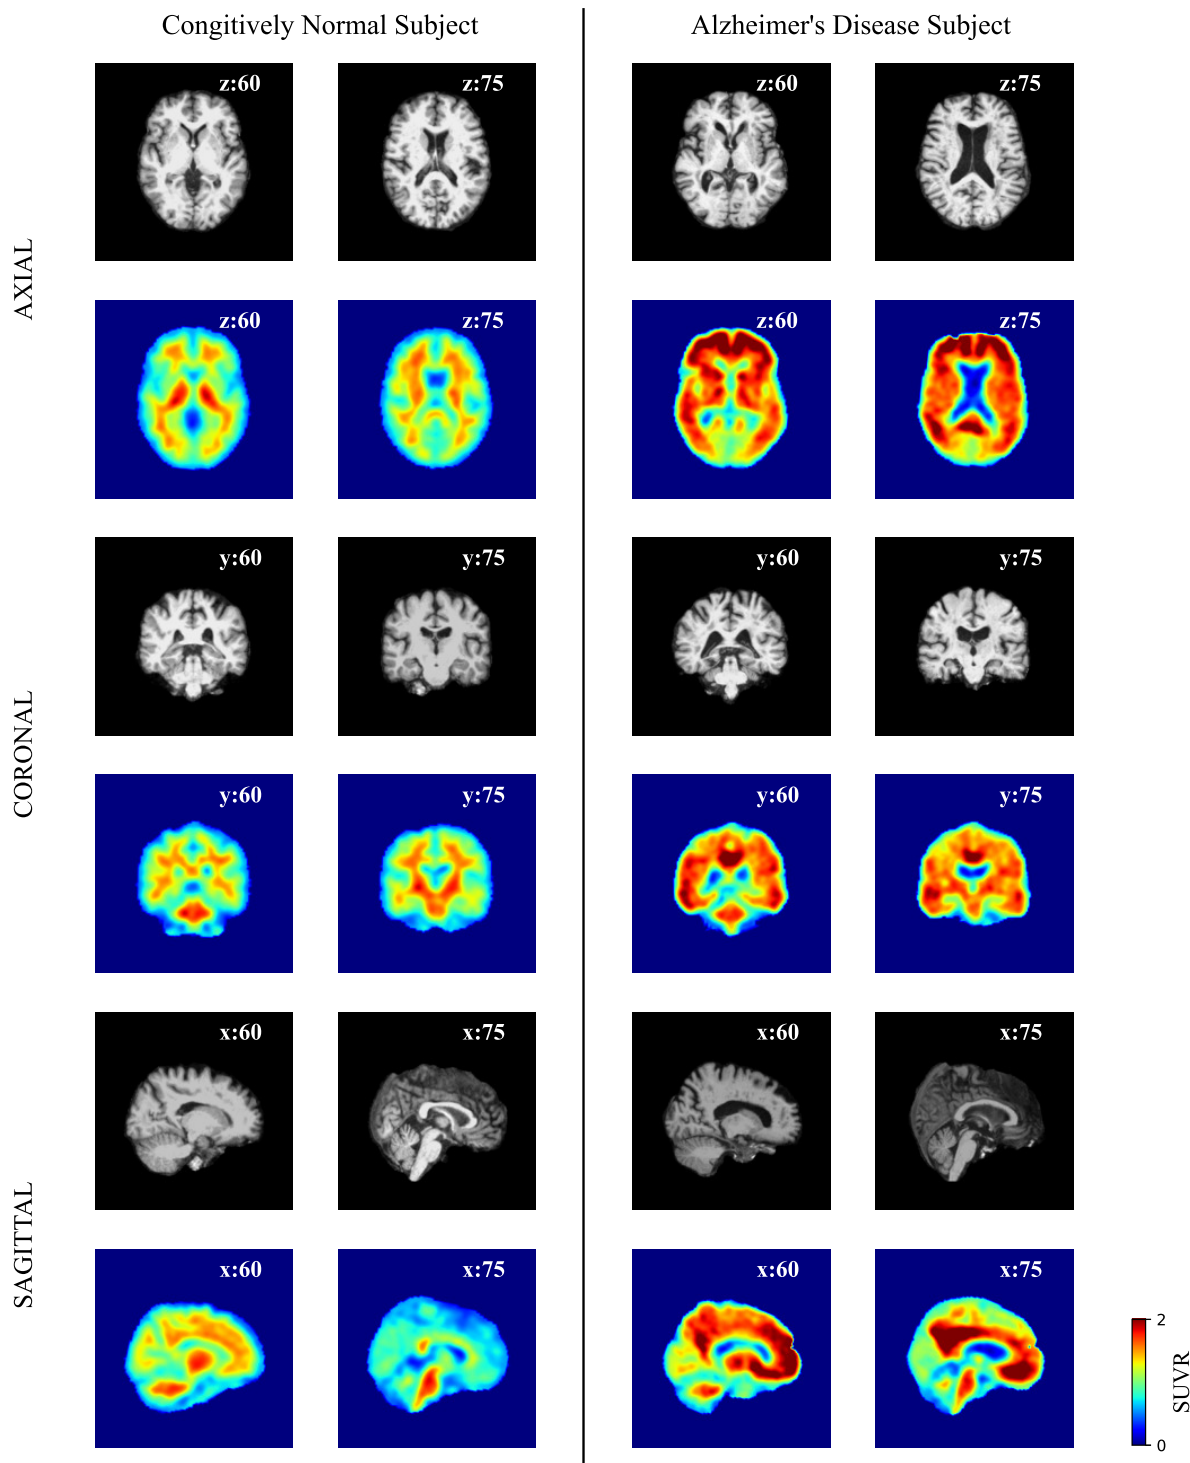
MRI and PET images for Cognitively Normal (CN) and Alzheimer's Disease (AD) subjects. Two slices in each orientation are shown with the numbers that correspond to the slice in the Montreal Neurological Institute (MNI) standard brain template. CN subject shows lower levels of brain atrophy (i.e., in the ventricles) with low amyloid-beta burden in comparison with AD subject. AD subject shows more atrophy and higher levels of amyloid-beta.
